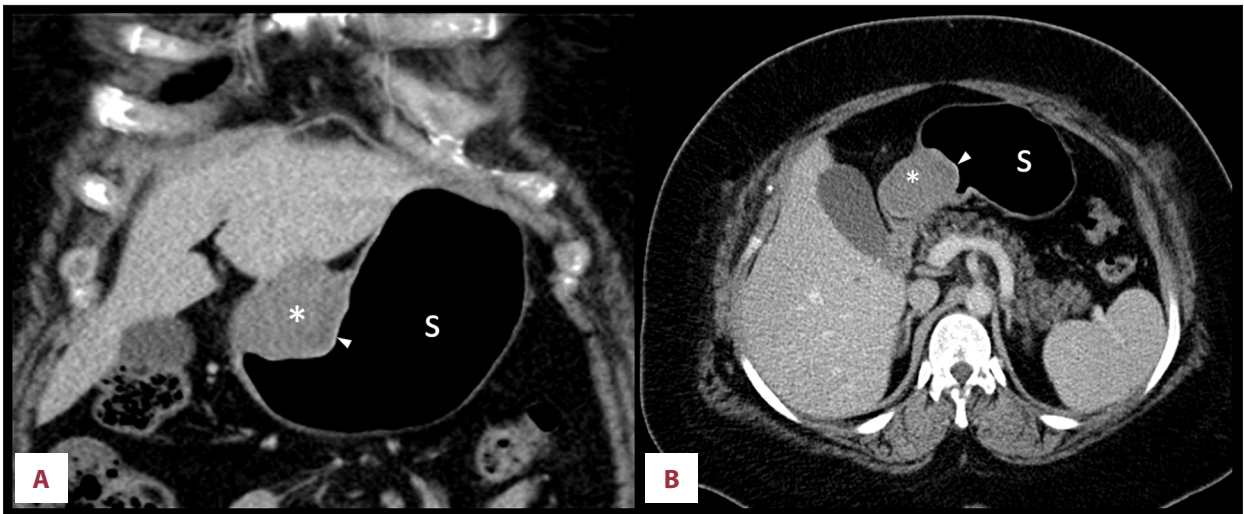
Contrast-enhanced abdominal computed tomography: Coronal (A) and axial (B) images demonstrating the presence of a large, hypodense, homogenous, soft tissue mass (asterisk) on the lesser curvature of the stomach (S), with normal overlying mucosa (arrowhead).
